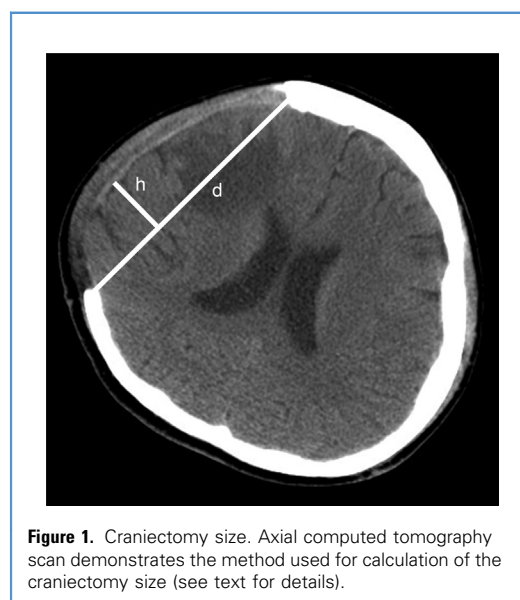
Craniectomy size. Axial computed tomography scan demonstrates the method used for calculation of the craniectomy size (see text for details).
